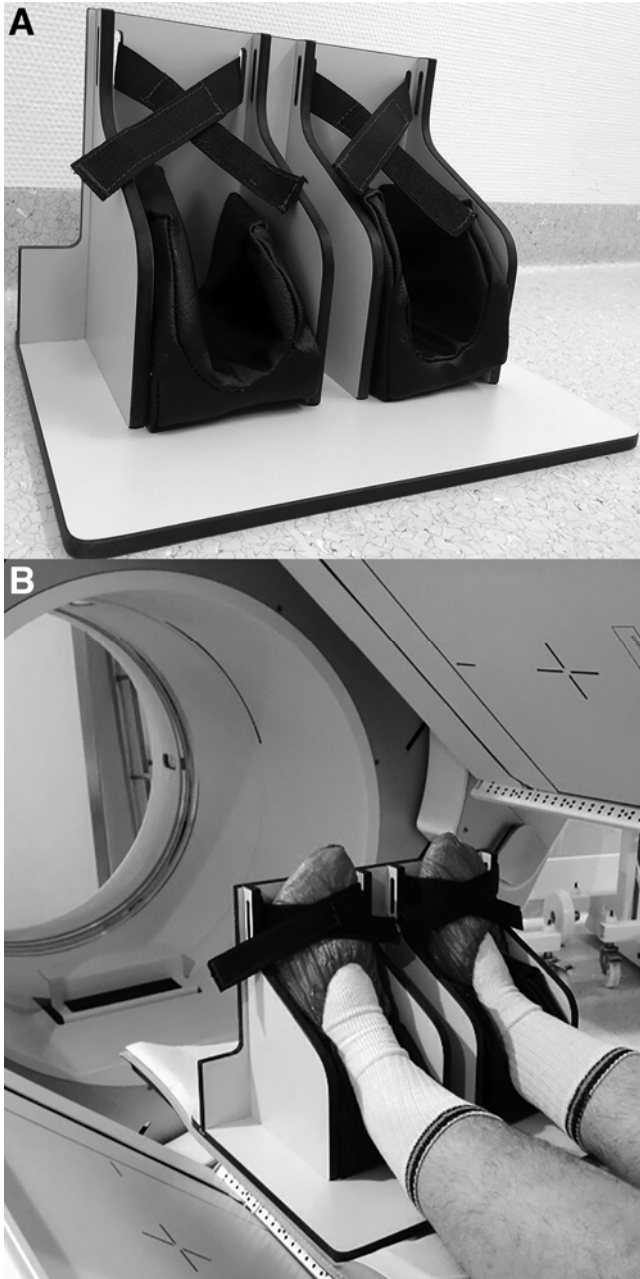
(A) Dedicated support for ankle/foot used for SPECT/CT acquisitions. (B) The foot is well fixed and retains an aligned position thanks to comfortable cushions.
